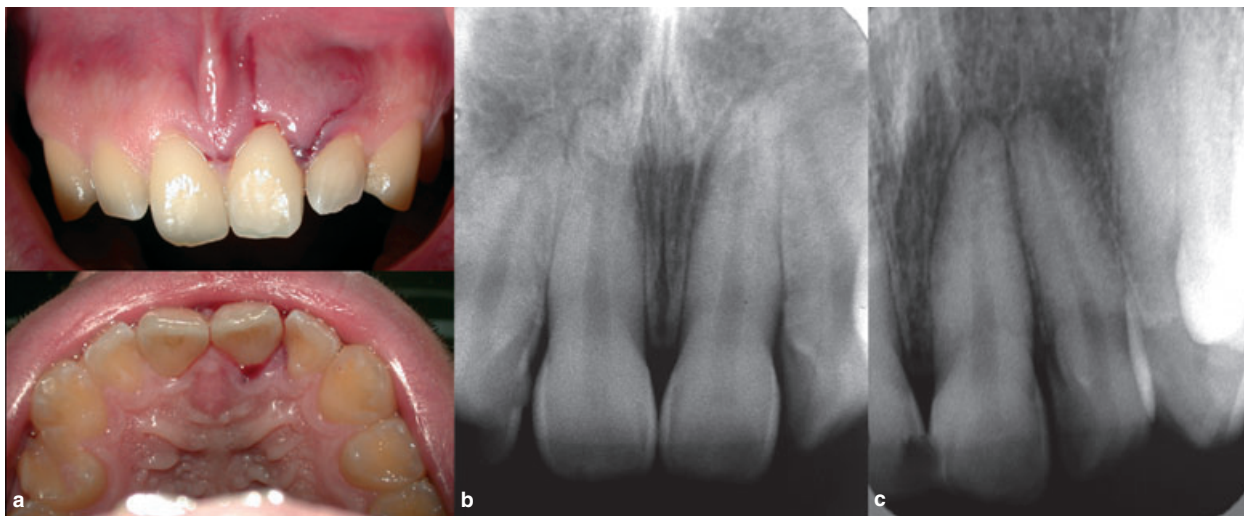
(a) Soft tissue lacerations on the attached gingiva and the upper lip. (b, c) Radiographs showing slight enlargement of the periodontal ligament space on the mesial and apical aspects of the maxillary left central incisor due to the traumatic displacement of the tooth.
